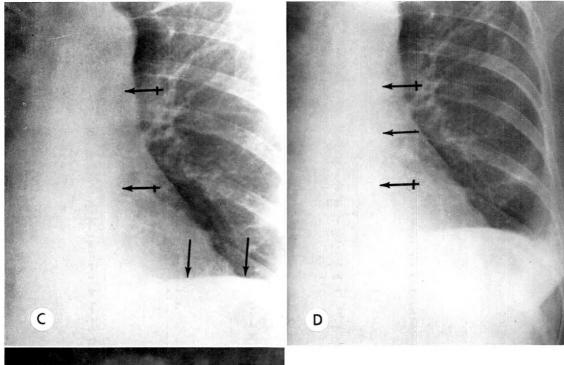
Case I. (A) A posteroanterior erect roentgenogram of May 18, 1965, taken 18 days after the termination of radiation therapy to the left lung and the left supraclavicular region. The aorta  $(\longleftrightarrow)$  is in normal position. The left paravertebral line is not identified. (B) A supine anteroposterior overexposed grid roentgenogram May 18, 1965, demonstrating a normal relationship of the left paravertebral line  $(\leftarrow)$  and aortic shadow  $(\hookleftarrow)$ .
